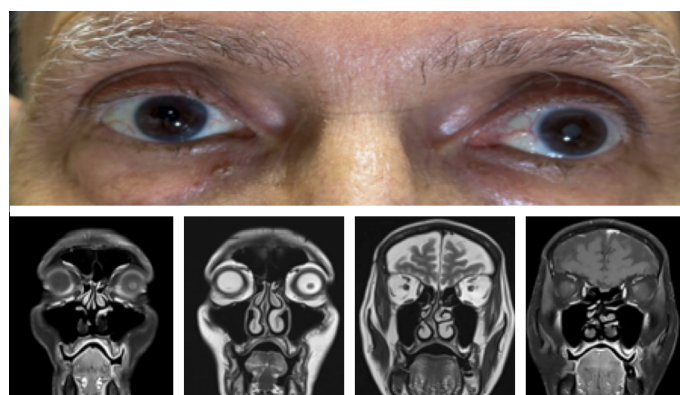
External view of the patient after treatment. In the MRI taken after the treatment, it was observed that the size of the lesion located anteriorly in the medial left orbit had significantly regressed, and the lesion located posteriorly in the medial left orbit had completely disappeared.
